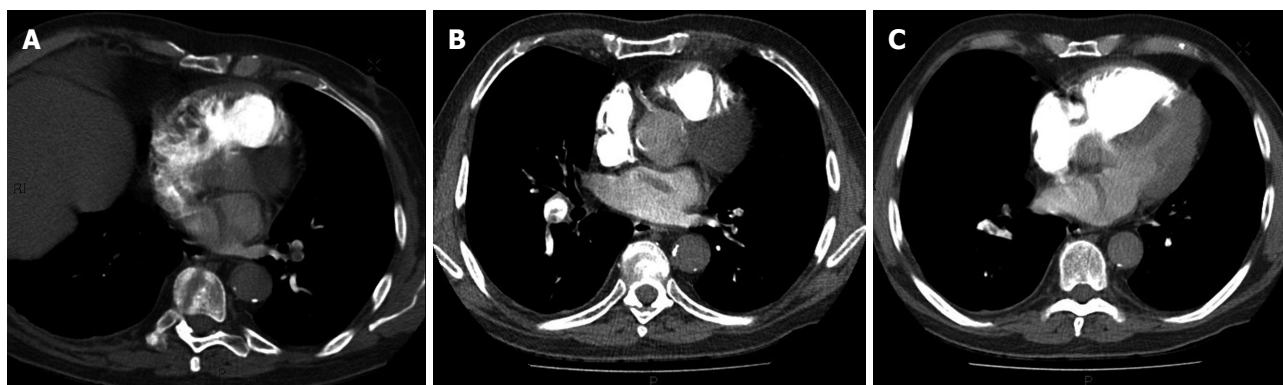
Findings at computed tomographic pulmonary angiography. A: Computer tomography pulmonary angiogram (CTPA) demonstrating a serpiginous low attenuation filling defect in the left atrium which extends across into the right atrium through a patent foramen ovale representing a paradoxical embolus (oblique axial view). There are also filling defects in the left lower lobe pulmonary artery due to pulmonary emboli; B: Demonstrating a filling defect in the left atrium filling defects in the right lower lobe pulmonary artery due to pulmonary emboli (axial view); C: CTPA demonstrating a filling defect in the left atrium, abutting the intra-atrial septum and bowing of the intra-ventricular septum due to raised right heart pressure (axial view).
